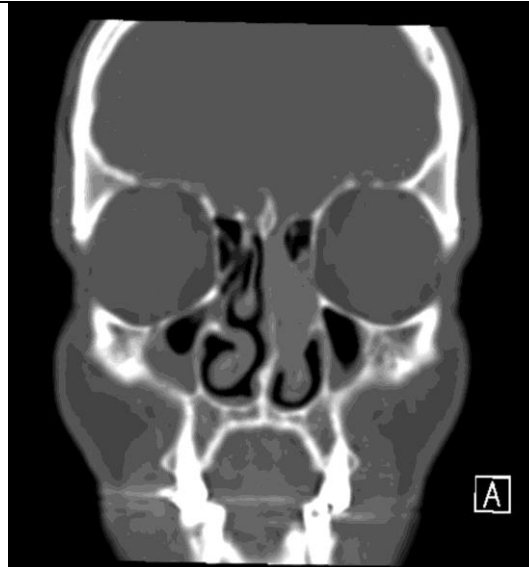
Contrast-enhanced CT scan of the paranasal sinuses, coronal reconstruction. An expansile, homogeneously enhancing soft-tissue mass measuring 42 mm in greatest dimension is demonstrated within the left nasal cavity, without associated bony erosion or sinus invasion. Note the bilateral chronic maxillary sinusitis and the absence of the right frontal sinus.
